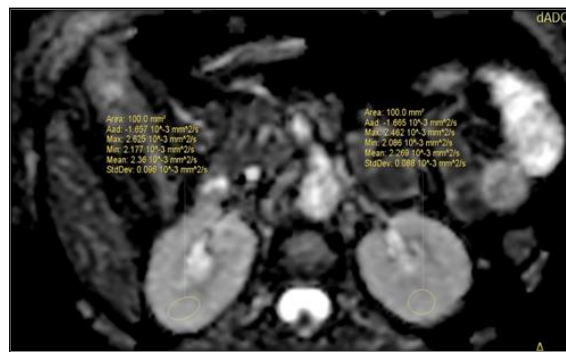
MRI DWI image showing ADC values
